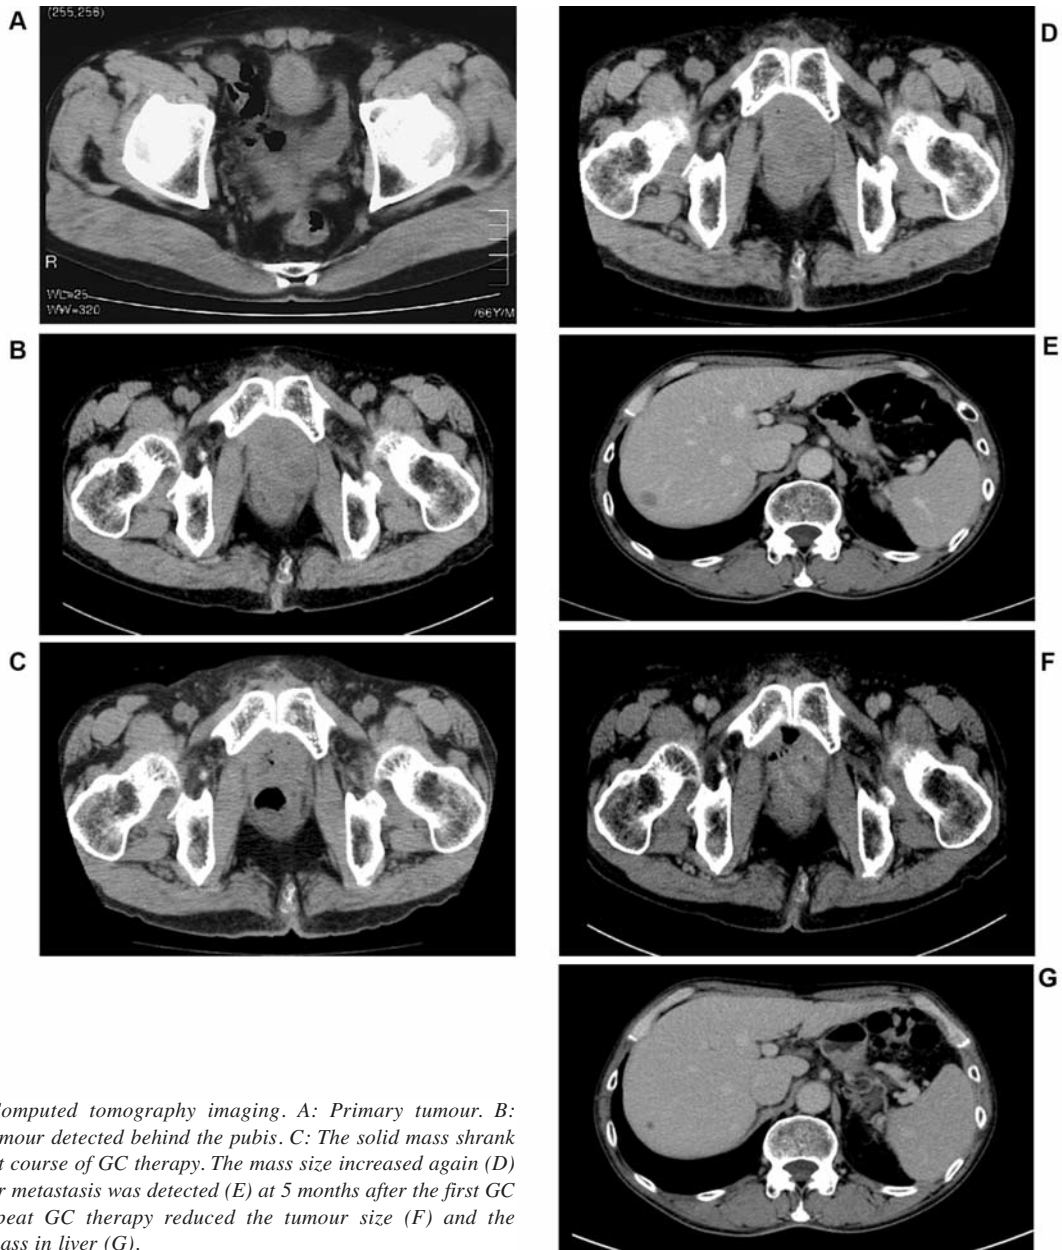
Computed tomography imaging. A: Primary tumour. B: Recurrent tumour detected behind the pubis. C: The solid mass shrank after the first course of GC therapy. The mass size increased again (D) and new liver metastasis was detected (E) at 5 months after the first GC therapy. Repeat GC therapy reduced the tumour size (F) and the metastatic mass in liver (G).
